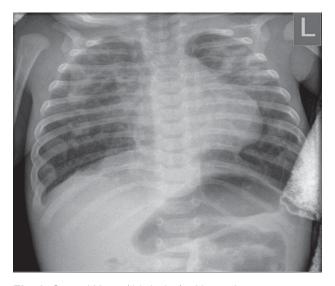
Control X-ray (14-th day) without changes
